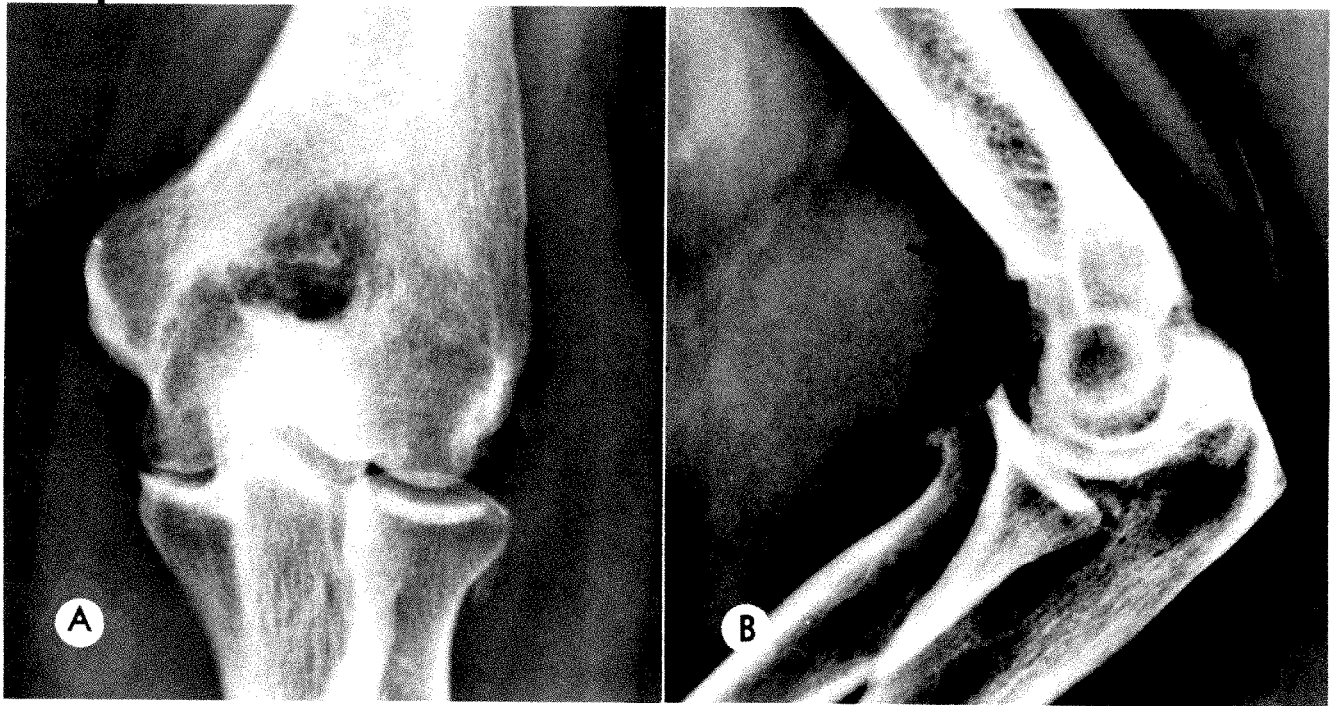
AP (A) and lateral (B) roentgenograms of right elbow showing soft tissue swelling about joint. Note multiple small, somewhat rounded and amorphous calcified densities overlying both joint space and capsule (arrows). Only minor degenerative osteophytes are seen. Articular surfaces are smooth and joint spaces are not narrowed.
